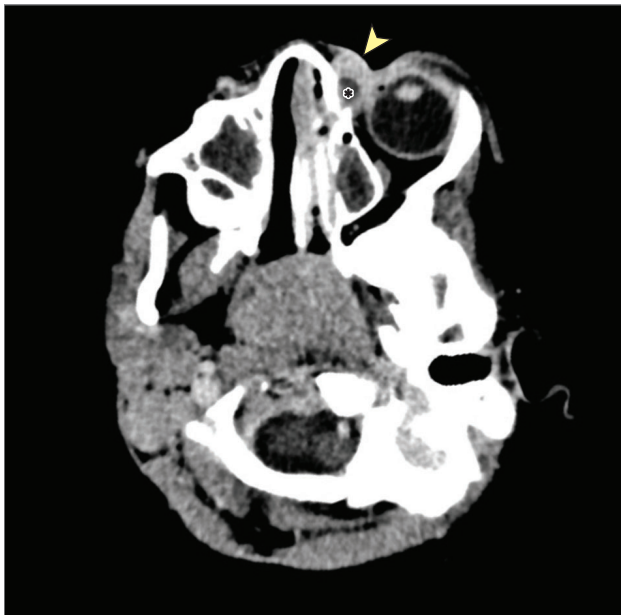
A, A 4-year-old child presented with left-sided swelling and erythema overlying the left lacrimal sac and left lower eyelid. Systemic examination revealed cervical lymphadenopathy and hepatosplenomegaly. B, A computed tomography (CT) scan of the orbits with contrast showed a 17 × 13-mm collection within the left lacrimal sac (asterisk) and adjacent soft tissue thickening (arrowhead), consistent with acute left-sided dacryocystitis, lymphadenopathy, and hepatosplenomegaly.
